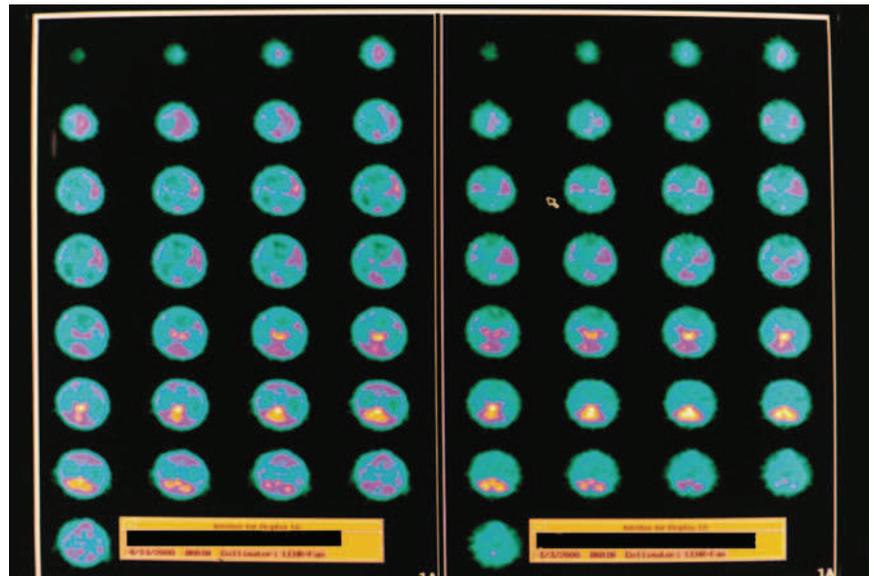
ECD SPECT brain imaging transverse slices. Baseline study is on the right again and study after 80 HBO treatments is on the left. Note the improvement in cortical blood flow after HBO
